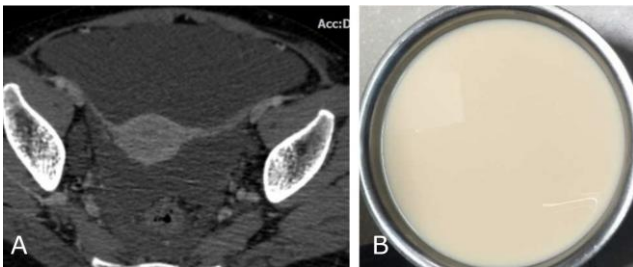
Abdominal CT scanner and fluid before treatment; Abdominal CT scanner revealed a large amount of fluid intraperitoneal and right pleural cavities (not shown) (A); Fluid obtained by paracentesis from ascites in milky white (B)
